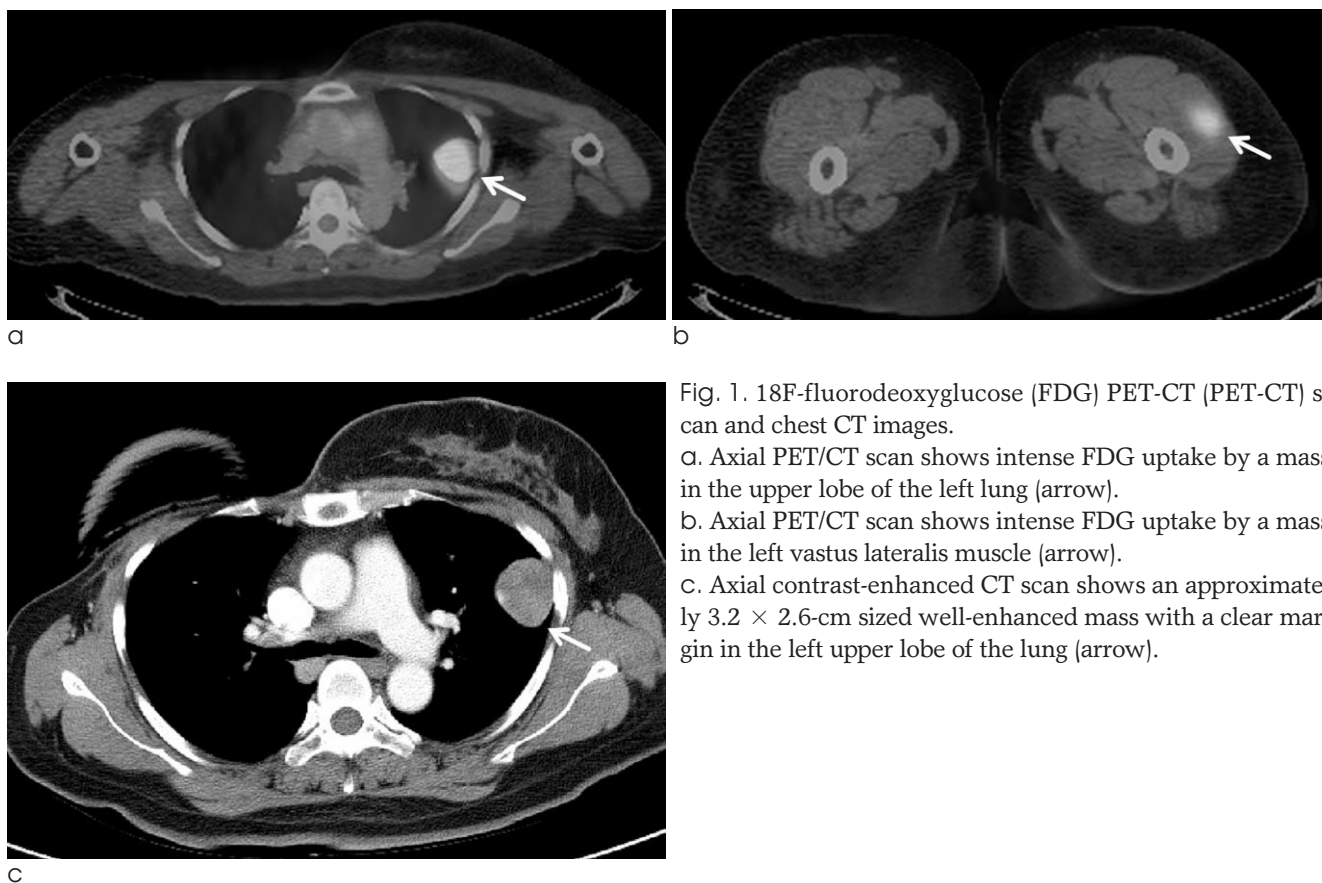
18F-fluorodeoxyglucose (FDG) PET-CT (PET-CT) scan and chest CT images.
